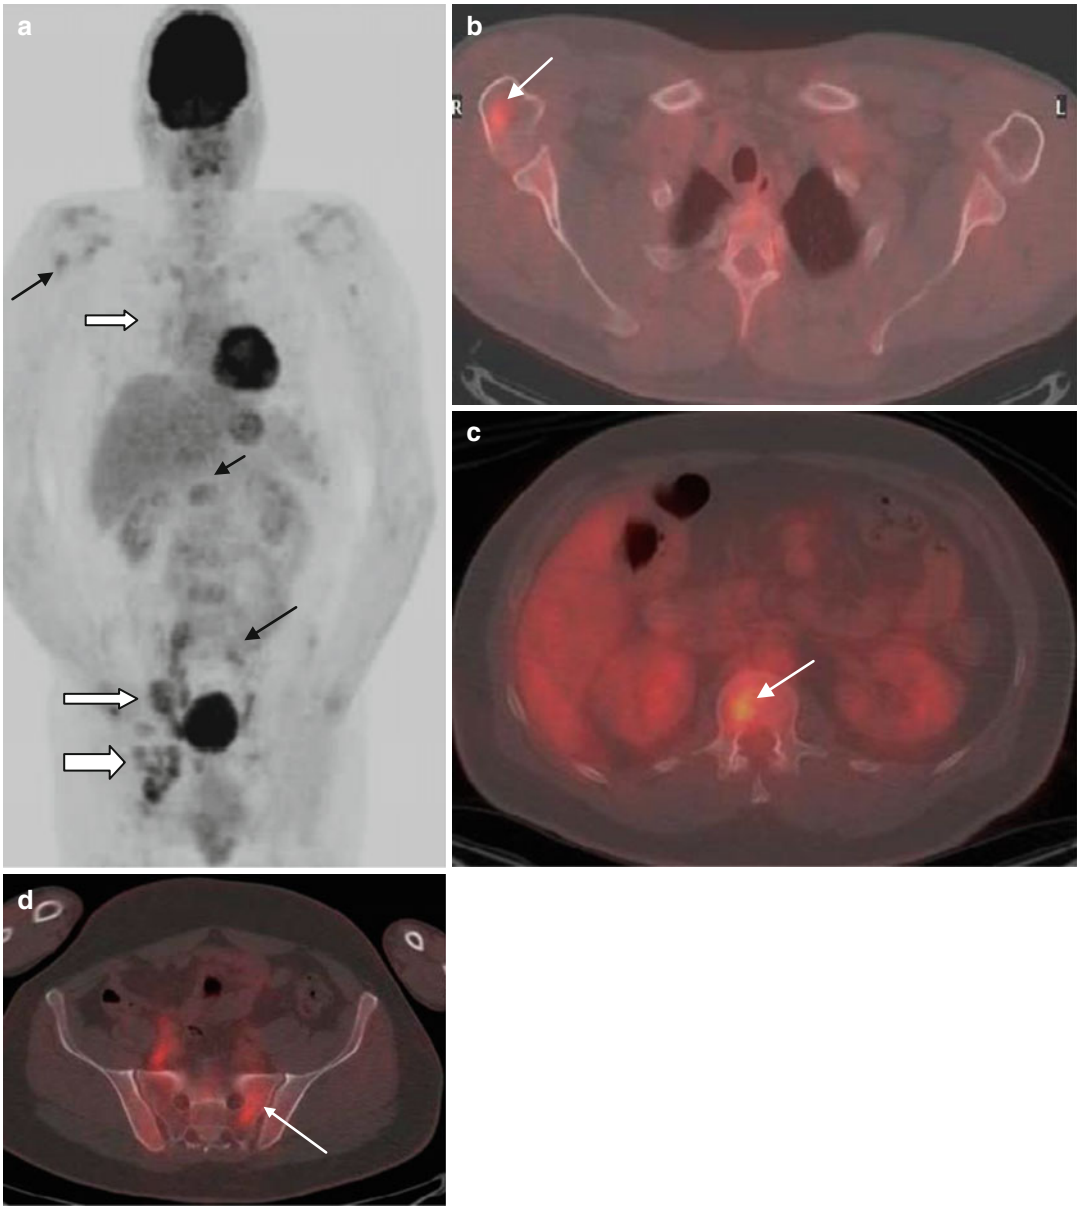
Staging PET/CT (a–d). Mild 18-FDG uptake (SUVmax 3.5) in mediastinal, abdominal, and pelvic lymph nodes (a – open arrows) but also mild abnormal
